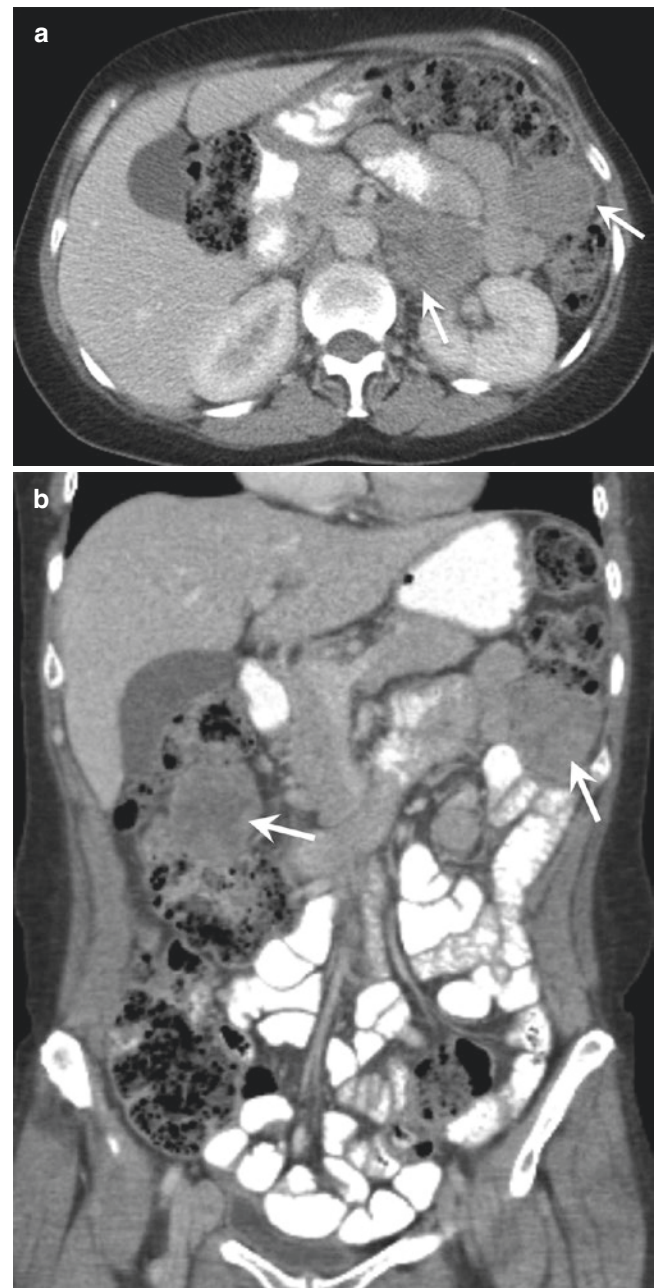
Melanoma metastasis to small bowel. Axial (a) and coronal (b) CT images in a patient with metastatic melanoma, with multiple small bowel masses (arrows)
